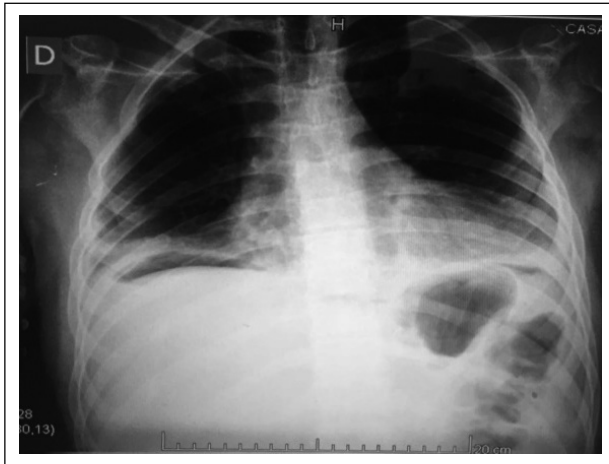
Chest radiography with pneumoperitoneum.
